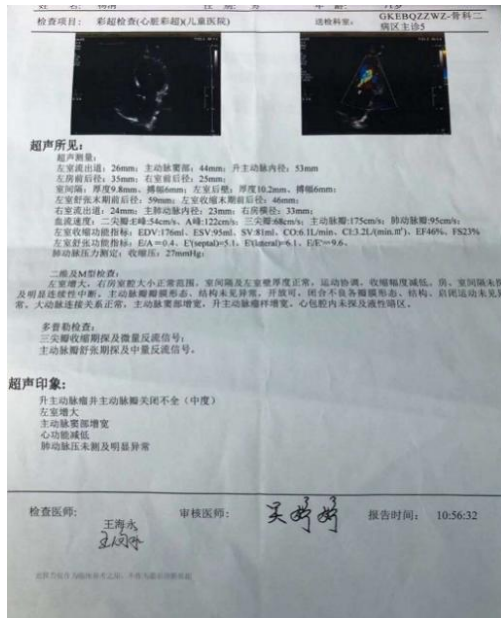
Echocardiographic
